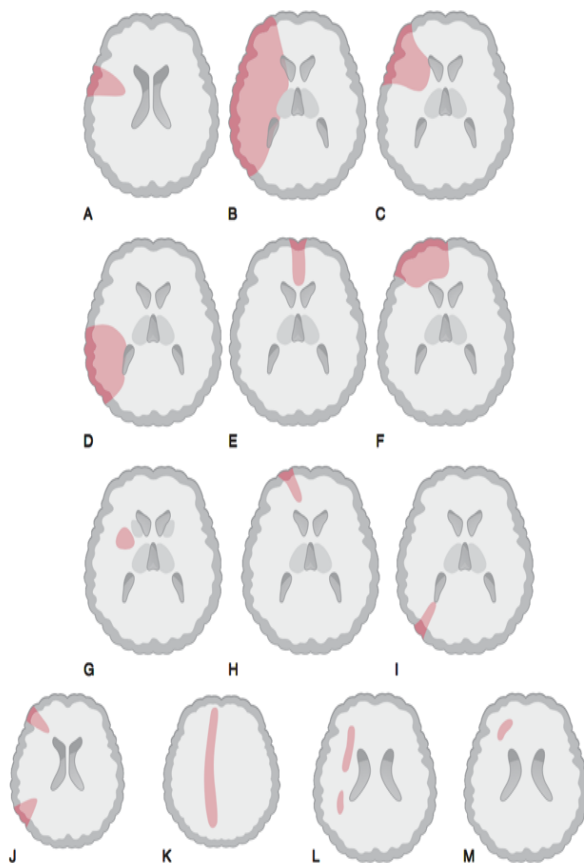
Common CT-locations of anterior circulation infarcts. (A) wedge-shaped MCA infarct, (B) entire MCA territory, (C) superior-division MCA, (D) inferior division MCA, (E) ACA, (F) ACA and MCA, (G) striatocapsular infarct, (H) wedge-shaped anterior watershed infarct, (I) wedge-shaped posterior watershed infarct, (J) anterior and posterior watershed infarcts, (K) linear watershed infarct, (L) ovular deep watershed infarct, and (M) small white-matter watershed infarct. Reproduced from Caplans' *Stroke: A Clinical Approach*, 2009 (36). Permission for use obtained from Elsevier.
